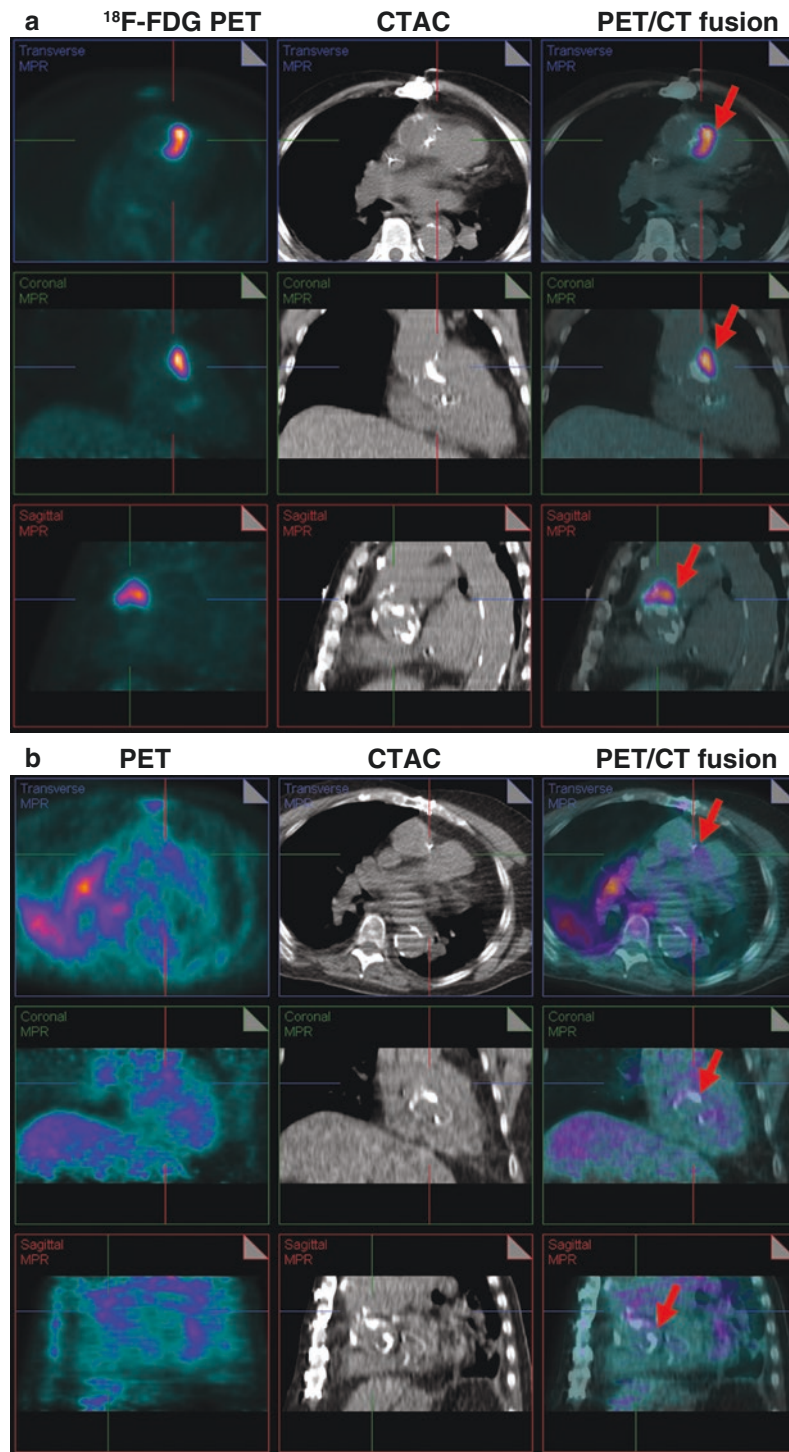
Utility of ^{18}F -FDG PET/CT in identifying infected prosthetic material. An 88-year-old man with three prior aortic valve replacements and aortic root repair presented with fevers and blood cultures positive for *Escherichia coli*. A transesophageal echocardiogram was unrevealing. (a) Because of persistent fevers, an ^{18}F -FDG PET scan was performed, which showed focal intense ^{18}F -FDG uptake in the region of the ascending aorta (red arrows). The corresponding region on the non-contrast CT scan
